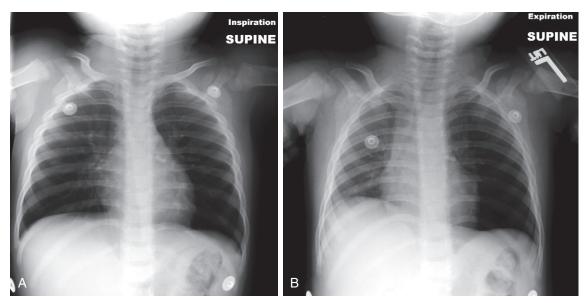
Foreign body. Inspiratory (A) and expiratory (B) radiographs of a child with an inhaled foreign body lodged in the left mainstem bronchus reveal hyperlucency of the left hemithorax and compensatory shift of the mediastinal structures to the right on expiration. (Courtesy Sameh Tadros, MD, Pittsburgh, Pa.)
